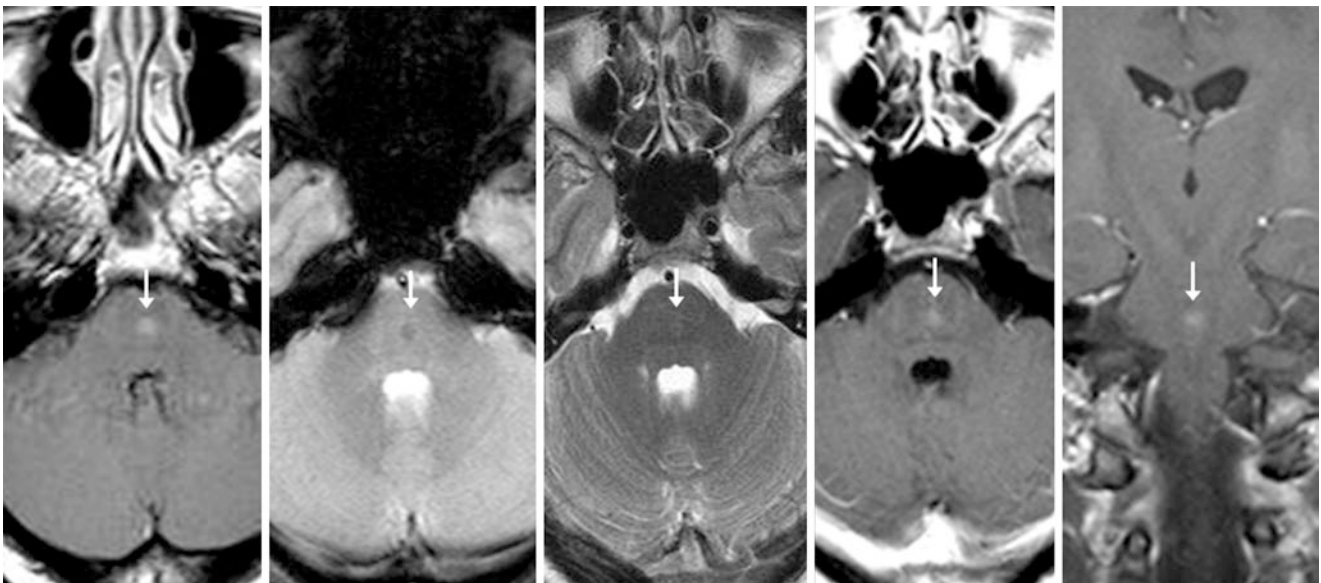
A 26 year old who had a frontal tumor (not shown). Mild enhancement is demonstrated within a pontine BCT (arrows) on a 1.5T MRI with postcontrast T1WI (left). There is a puff of dark signal on GE T2*WI (left middle), with a normal T2WI (middle). Postcontrast axial (right middle) and coronal (right) T1WIs 3 years later show no change
